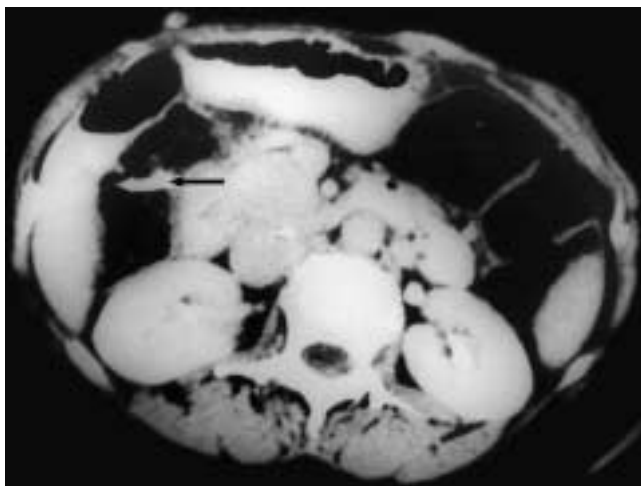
Axial computed tomography (CT) scan of the abdomen; arrow indicates perforated stent in colon
